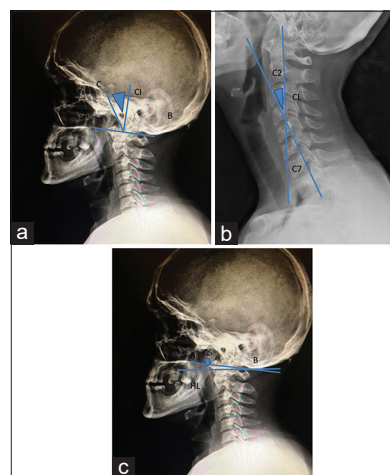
CI angle (a), CL (b) and CS (c) measurements on the lateral cervical roentgenogram (a: Hard plate; b: Opisthion; c: Sella Turcica; CI - Cranial incidence angle, CL - Cervical lordosis angle, CS - Cranial slope)
